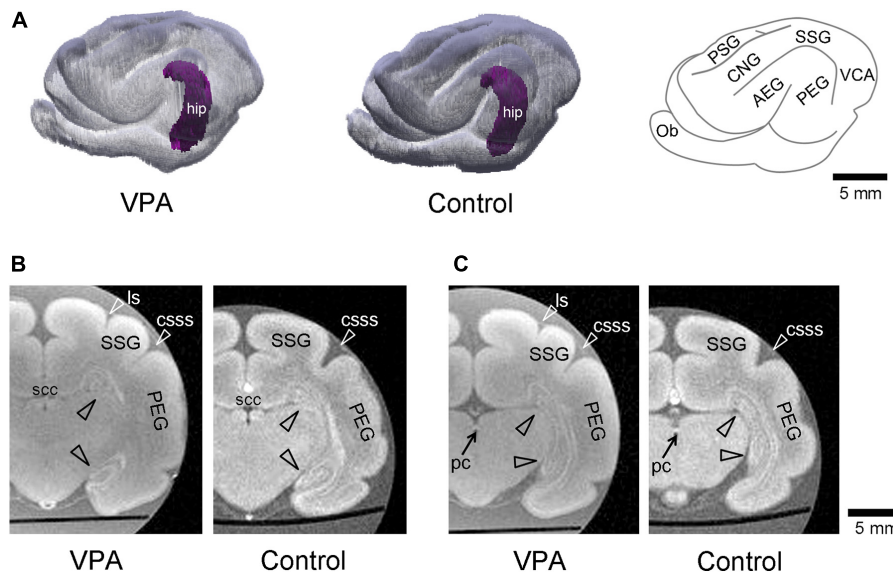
Three-dimensional volume-rendered images in cerebrum with the hippocampus of the postnatal day (PD) 20 ferrets. (A) The left and moderate images are reconstructed images of the cerebral cortex and hippocampus (hip; purple) of the left hemisphere in valproic acid (VPA)-treated and control ferrets, respectively. A gyral map of the left hemisphere is shown on the right. (B) Coronal ex vivo magnetic resonance (MR) images [using RARE sequence with short repetition time (TR) and minimum time to echo (TE) setting] of cerebrum including the hippocampus at the caudal end of the splenium of corpus callosum from VPA-treated ferret (left) and control one (right). (C) Coronal ex vivo MR images of cerebrum including the hippocampus at the posterior commissure from VPA-treated ferret (left) and control one (right). AEG, anterior ectosylvian gyrus; CNG, coronal gyrus; csss, caudal suprasylvian sulcus; Ob, olfactory bulb; ls, lateral sulcus; pc, posterior commissure; PEG, posterior ectosylvian gyrus; PSG, posterior sigmoid gyrus; scc, splenium of the corpus callosum; SSG, suprasylvian gyrus; VCA, visual cortical area.
